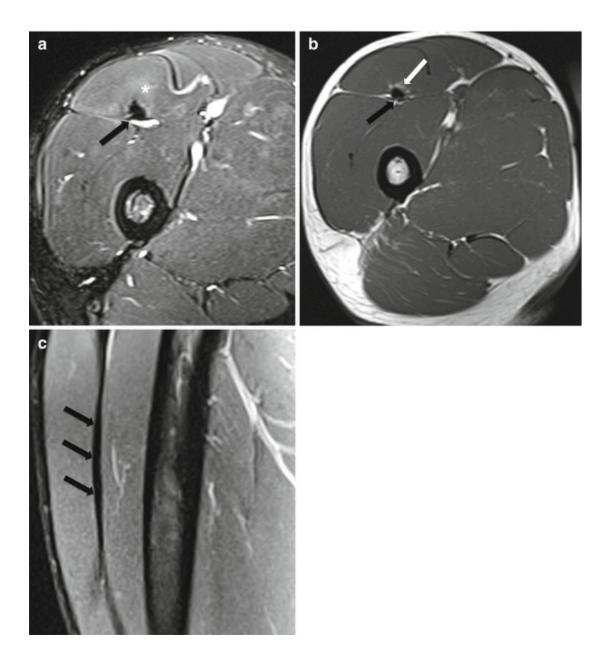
A 35-year-old male athlete with a chronic peripheral myotendinous injury at the mid belly of left rectus femoris. Axial (a) fat-suppressed T2- and (b) T1-weighted MRI show a low-signal fibrous scar at the point of contact of posterior myotendinous junction (black arrow) with slight hyperintensity within the muscle fibers (asterisk) and focal fatty infiltration (white arrow) in keeping with an old injury. (c) Sagittal fat-suppressed T2-weighted MRI show the longitudinal course of the fibrous scar (arrows)
